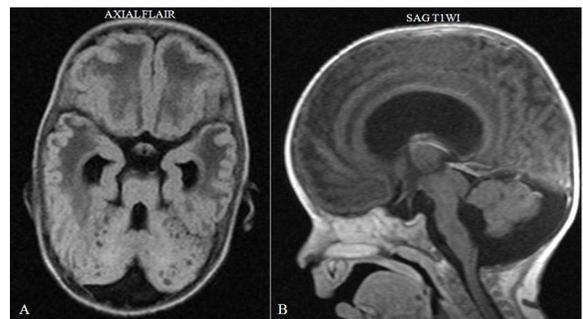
Axial FLAIR image reveal multiple small cerebellar subcortical cysts with pachygyria in bilateral frontal regions (4A). Hypoplasia of pons and cerebellum noted with dorsal kink at the pontomesencephalic junction and fusion of colliculi (Fig. 4 B). Moderate hydrocephalus is seen with stretching of corpus callosum.
